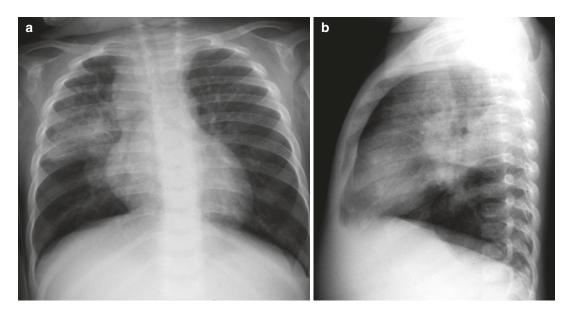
Tuberculosis in a young boy. (a, b) Frontal and lateral radiographs of the chest demonstrate a right upper lobe opacity and associated right hilar lymphadenopathy
